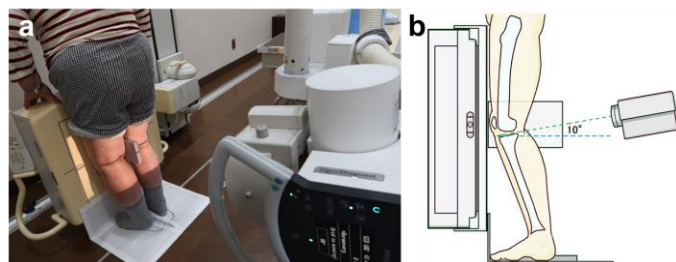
FFV radiography methods.
